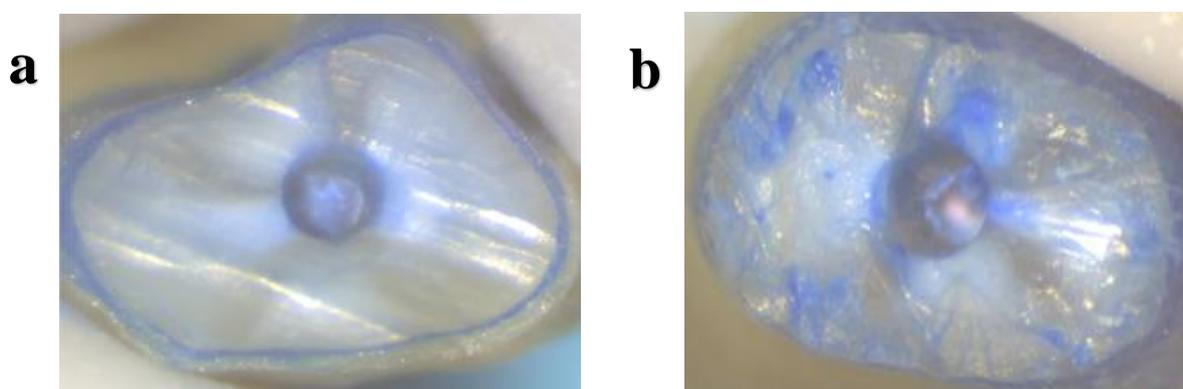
Root surface after root resection by conventional bur (a), and ultrasonic tip (b), after root end preparation by ultrasonic retrograde tip.
